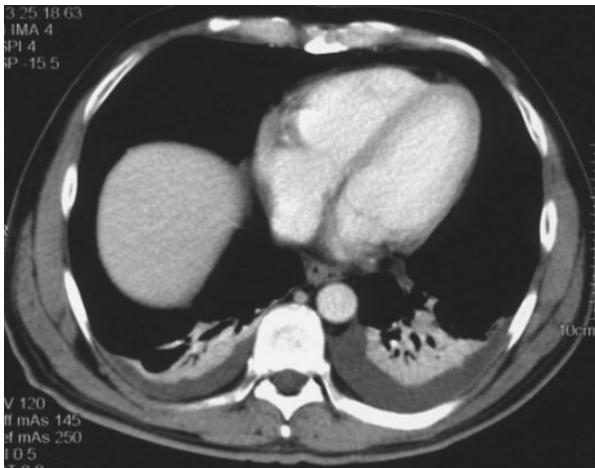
Multidetector computed tomography scan: pleural effusion.
